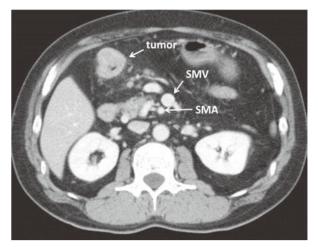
The presence of the superior mesenteric vein to the left of the superior mesenteric artery is called the SMV rotation sign (contrast-enhanced CT of the abdomen).
